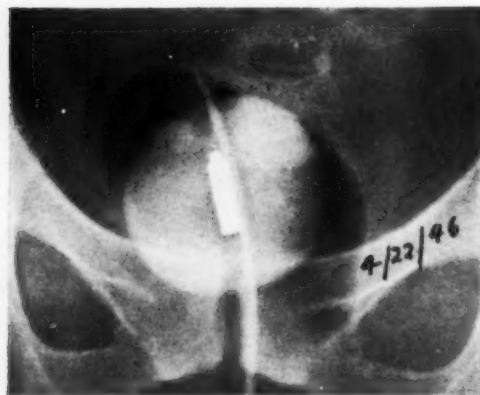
Case 1. Radium in a three-channel catheter, used without cystotomy. This procedure is not recommended, as the drainage channel frequently becomes obstructed and the urine readily pushes the bladder wall and tumor away from the surface of the balloon. The roentgenogram shows how the introduction of a small amount of air, under slight pressure, will push the bladder wall from the surface of the bag. The radium capsule used in the early cases contained 5 cells of 5 mg. radium each. Primary filtration of each cell was 0.2 mm. Pt; that of the capsule was 0.8 mm. Pt. This bulky capsule with irregular and heavy filtration is undesirable because it does not act like a point source.
